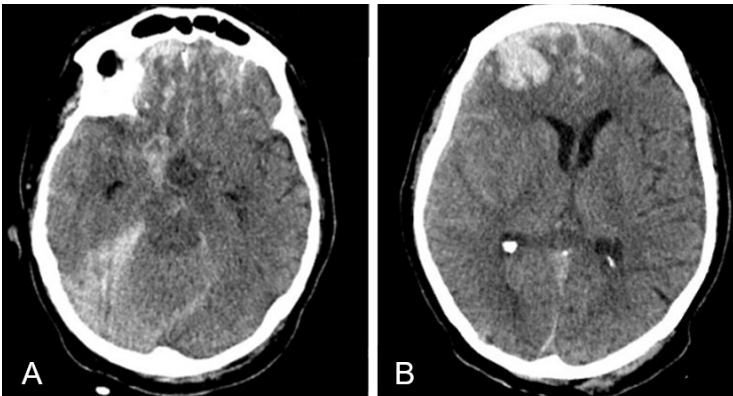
Basal head CT. Multiple subarachnoid hemorrhages at the anterior part of both frontal lobe and subdural hemorrhage along the right tentorium and the posterior part (A). A slight shift of the cerebral midline to the left (B).
